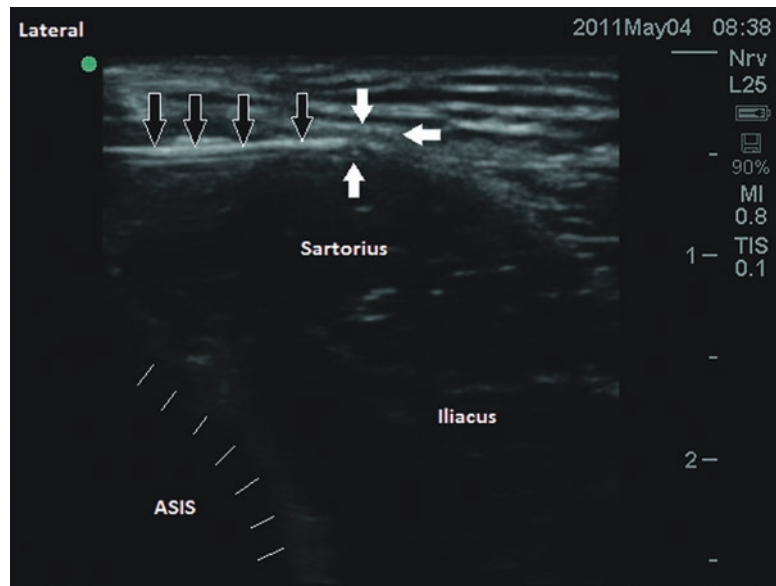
Ultrasound image showing needle (black arrows) in contact with LFCN (white arrows). The anterior superior iliac spine (ASIS) is outlined by solid white lines
